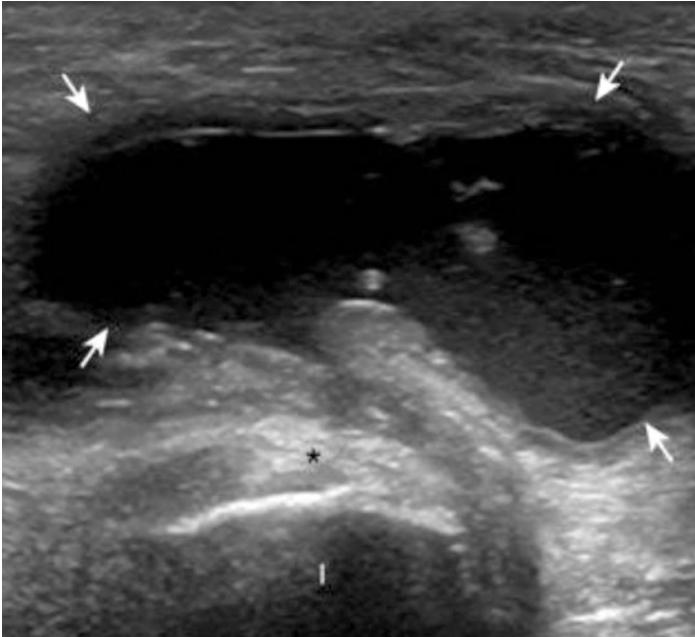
Ultrasound image arrows show the transverse plane of the ischium with hypoechoic complex bursa distention predominantly. *I* = ischium. (Adapted from Jacobson, J 2018 [9])
